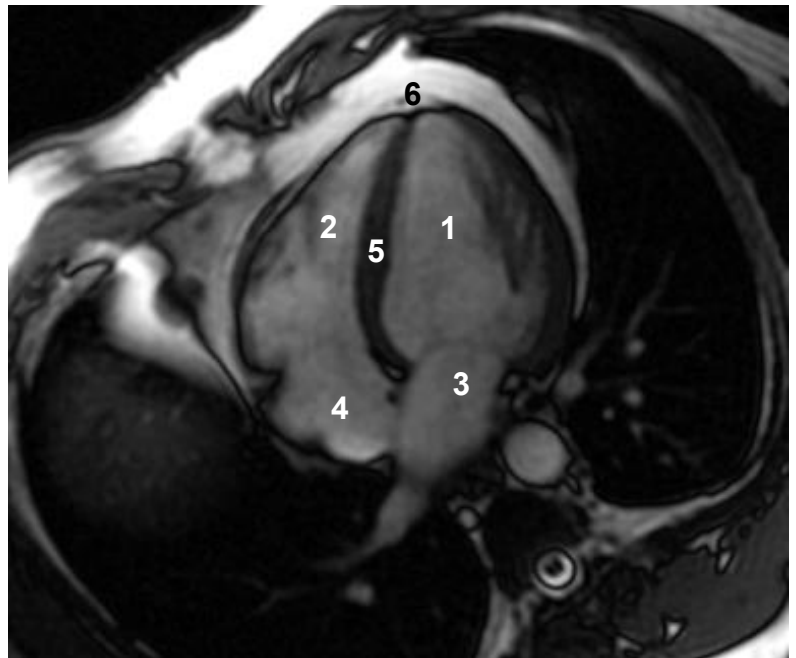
MRI of the heart. Anatomy of the heart from a horizontal long axis 4-chamber view.
